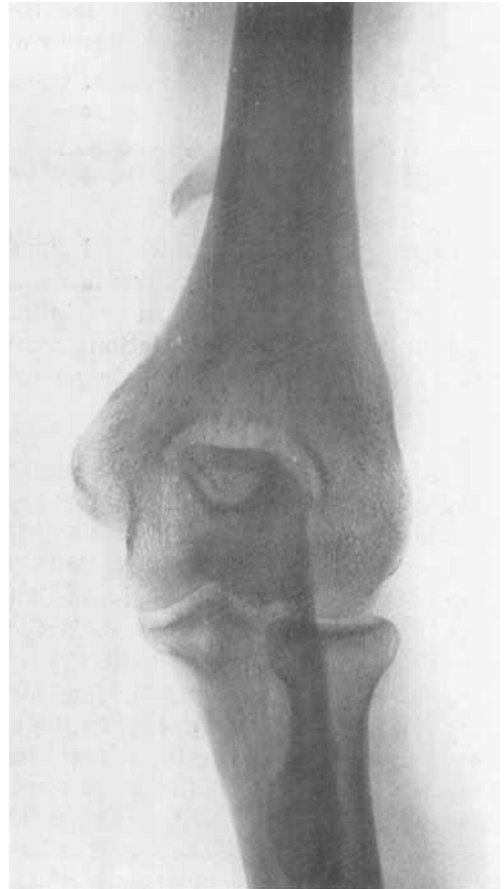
X-ray of the right humerus in our patient, showing the supracondyloid process.
